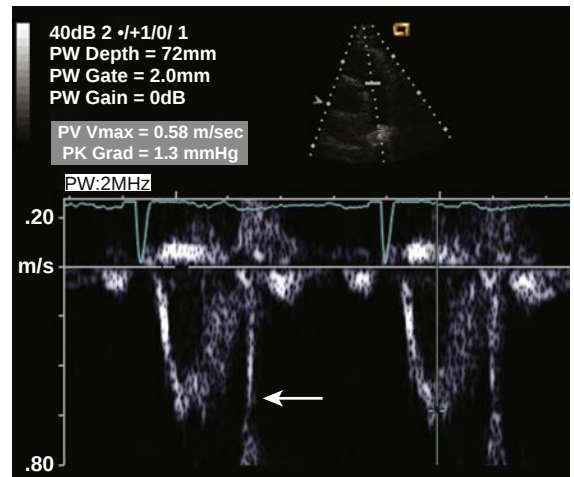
Pulsed Doppler recording of normal flow in the RV outflow tract. The pulmonic valve closure click indicates that the sample volume is on the RV side of the valve. Normal flow shows a smooth velocity curve that peaks in mid-systole with a velocity less than 1 m/s.
